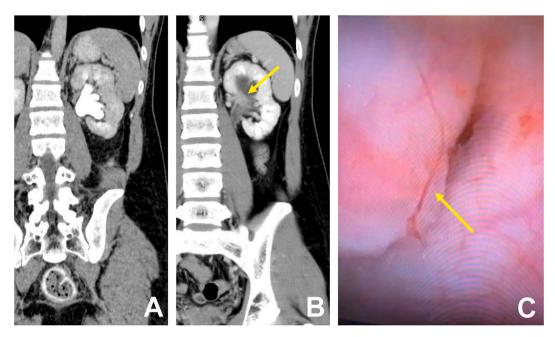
Initial CT scan; the delayed phase revealed left moderate hydronephrosis without filling defect in the renal pelvis (Fig. 1A). CT scan at the new episode of flank pain and gross hematuria; the venous phase demonstrated a 1.9-cm enhancing mass at the superior aspect of the left renal pelvis (1B). View from flexible ureterorenoscopy showed a submucosal mass corresponding to the CT scan finding (1C).
